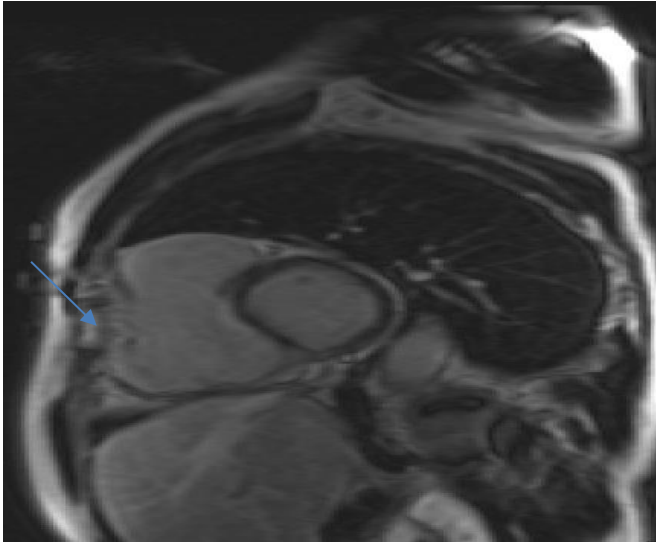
cardiac resonance magnetic (MRI): Sagittal sections showing the apical RV aneurysm (blue arrow)
